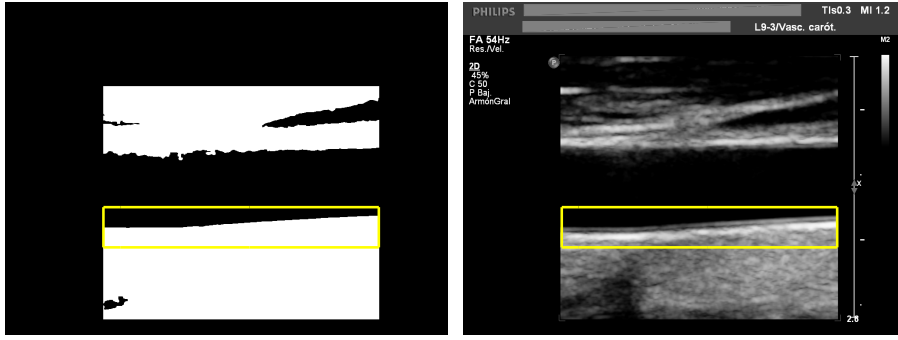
ROI selection for the ultrasound image in Fig. 1: (left) Final binary mask with selected ROI; (right) Original image with superimposed ROI.
